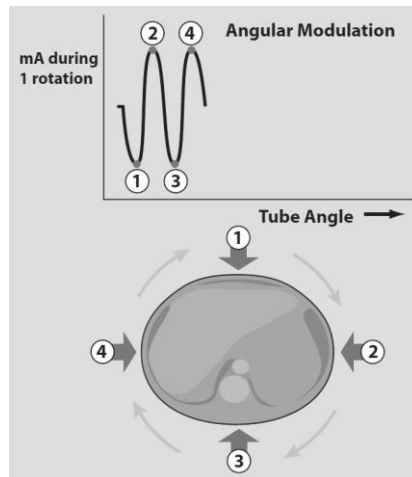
Modulation of the X-ray tube current in the transverse plane of the patient can be used as a technique to reduce the dose to the patient. Because of the elliptical shape of the human body, the attenuation in the LAT directions (2 and 4) will be higher compared to the AP directions (1 and 3). Therefore, tube current values can be lowered during the AP projections [5].
